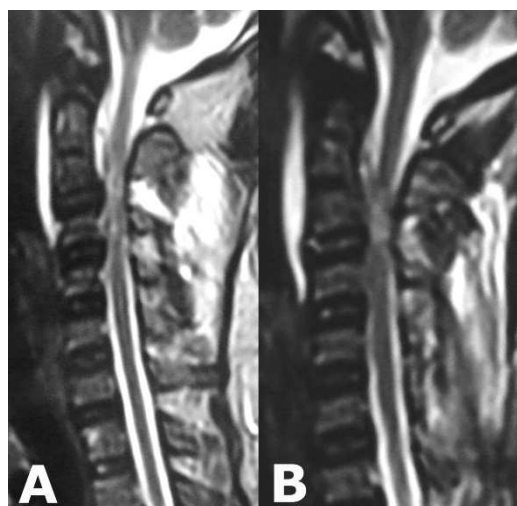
Magnetic resonance image T2-weighted sagittal images showing a large contusion at C2-3 level in the spinal cord with canal stenosis and C3-4 disc prolapse causing the compression of the dural tube
